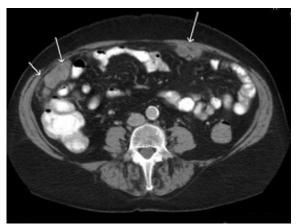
CT scan showing peritoneal metastases.
